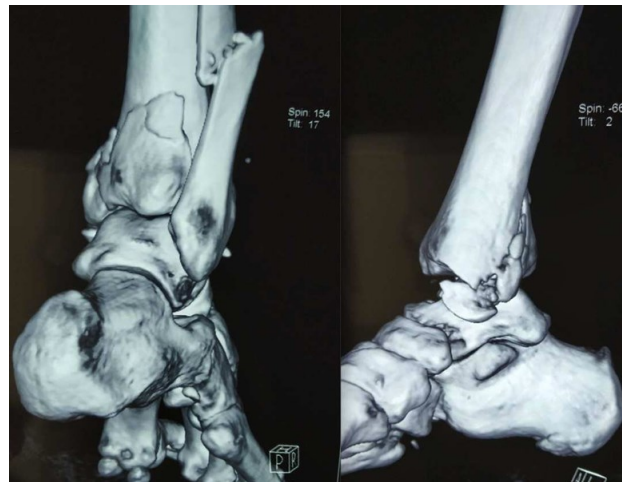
Picture showing 3D CT scan confirming posterior medial fragment of postero-malleolus.
